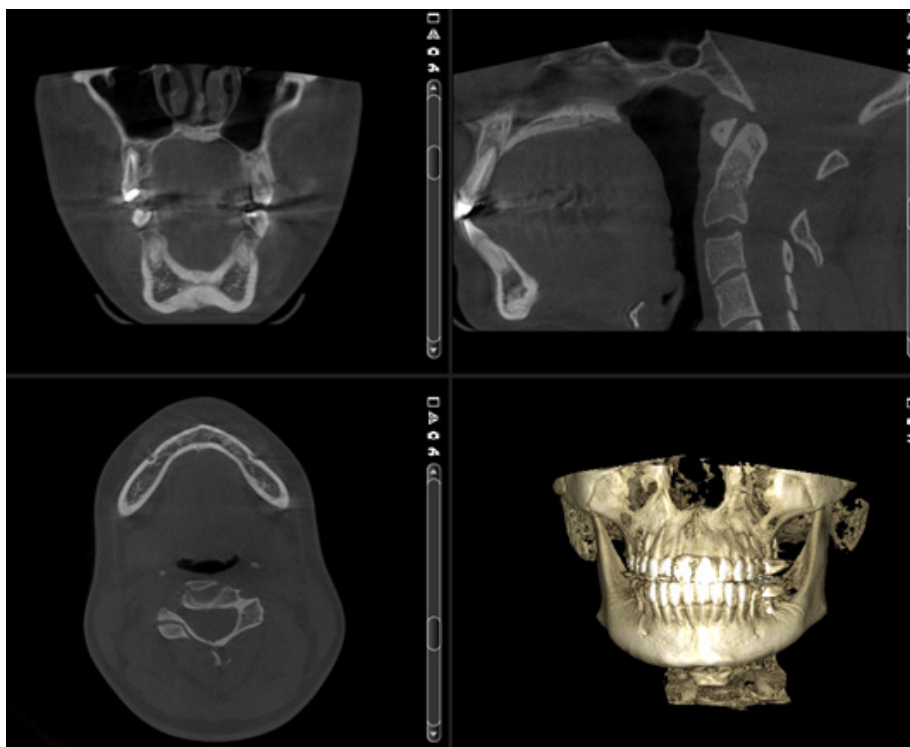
CBCT image of lingual foramen in all sections.
